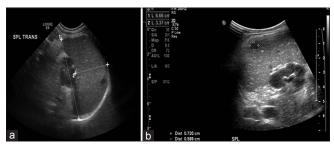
Sonogram of the abdomen showing splenomegaly (a), diffusely heterogeneous spleen and with hypoechoic subcentimeter splenic nodules (b), which could be secondary to fungal infection or multiple abscesses
